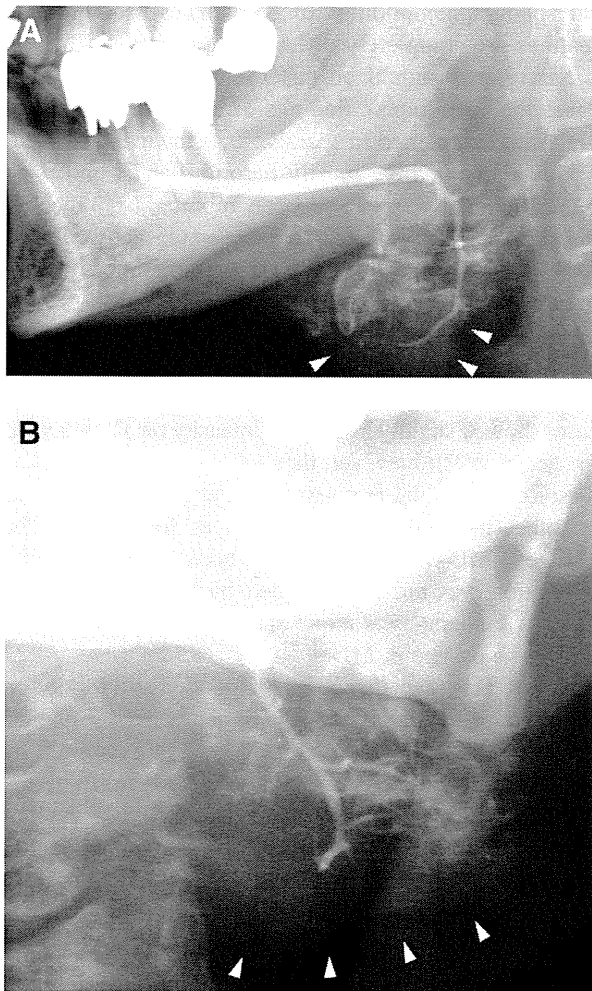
(A) Submandibular gland sialogram shows parenchymal defect (arrowheads) in accordance with the nodal area on the sonogram (lateral projection). (B) Same case as Fig. 5A in oblique projection. Note parenchymal defect (arrowheads).
